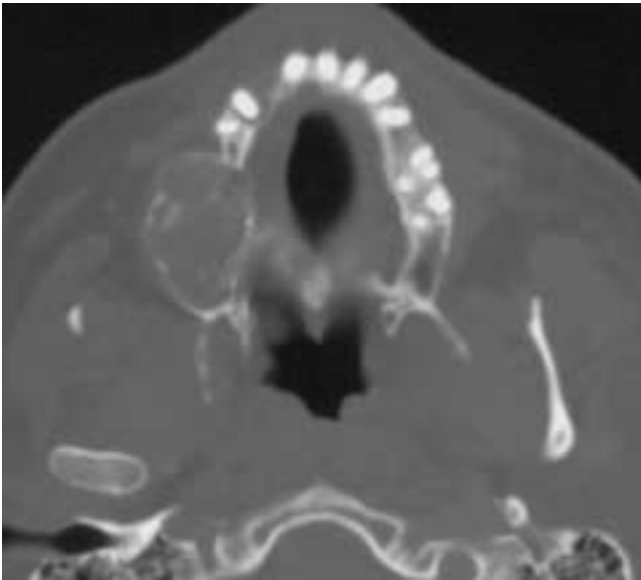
Giant cell lesion of the mandible. Axial CT scan. There is expansion of the alveolar process, and foci of mineralization are seen. The appearance of this lesion mimics that of fibrous dysplasia.
